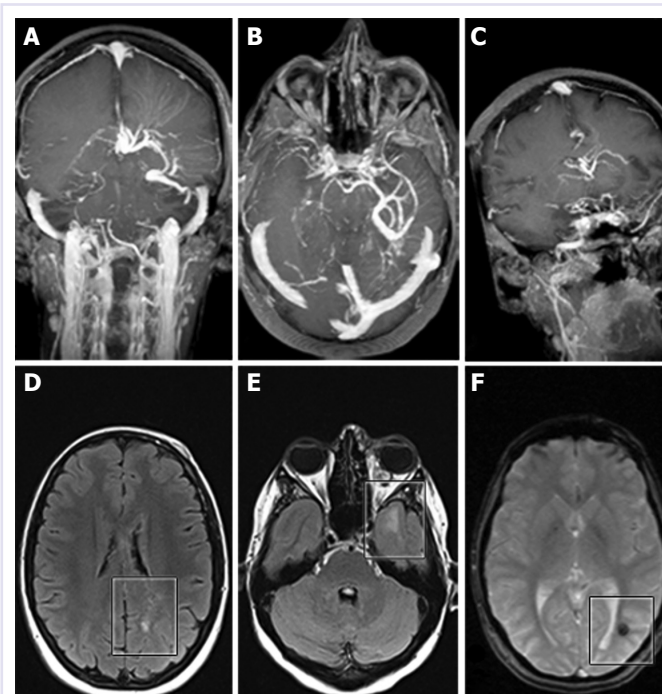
MIP reformatted images from contrast-enhanced gadolinium 3D MPRAGE sequences, on coronal (A), axial (B) and coronal-oblique (C) planes; axial FLAIR (D, E) and axial GRE T2* (F) images which show three intracranial DVAs of the left hemisphere: a parieto-occipital DVA with deep drainage (A); a DVA with two drainages in the perimesencephalic cistern and in the middle cranial fossa (B), with FLAIR hyperintense signals which suggests gliosis (D, E); a DVA in the fronto-insular region (C), with deep drainage in the vein of Galen; and a cavernous hemangioma in the subcortical occipital lobe.
